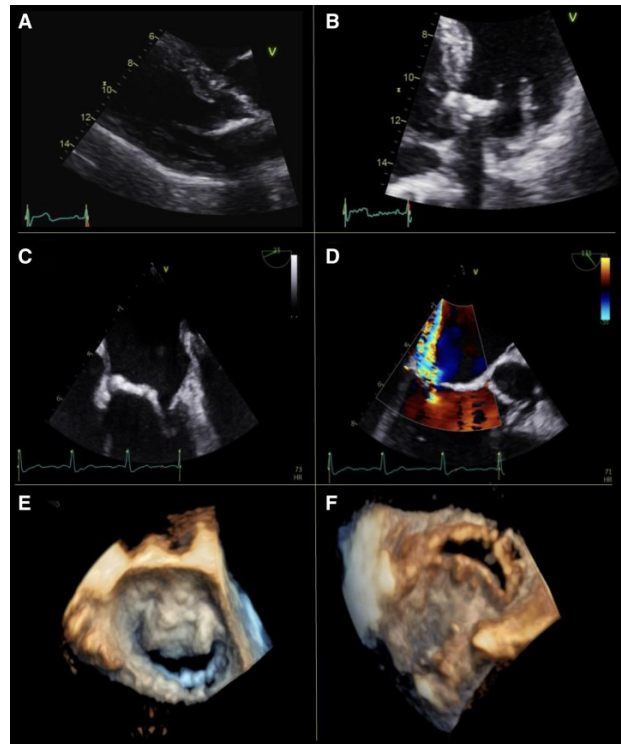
Echocardiographic findings in a 53-year-old woman who had previously received radiotherapy for lymphoma at the age of 42. Panels A-C (transthoracic and transesophageal echocardiography) reveal pronounced thickening and calcification of the basal anterior mitral leaflet and the aorto-mitral curtain. Panel D demonstrates a posteriorly directed jet of mitral regurgitation. Panels E and F show 4-dimensional reconstructions of the mitral valve, highlighting relative preservation of the leaflet tips and commissures, with panel E displaying a surgical perspective and panel F depicting the view from the left ventricle.
